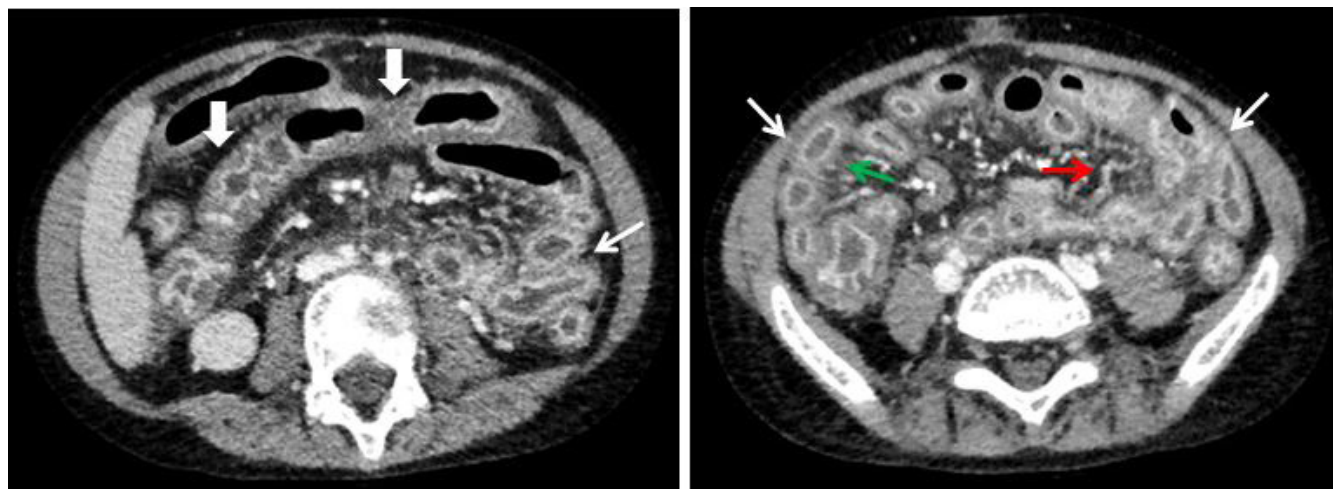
Axial contrast-enhanced CT images of the abdomen and pelvis. There is diffuse mural thickening and increased mucosal enhancement of the small (thin white arrows) and large bowel (thick white arrows), with associated engorgement of the vasa recta (red arrow) and mesenteric stranding (green arrow). The bowel is diffusely fluid filled, consistent with patient's history of diarrhea.
